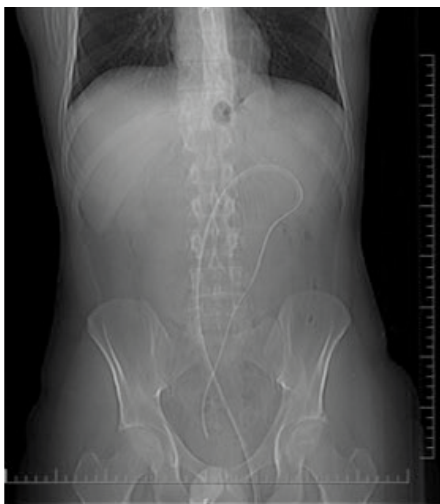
Plain abdominal radiograph.
